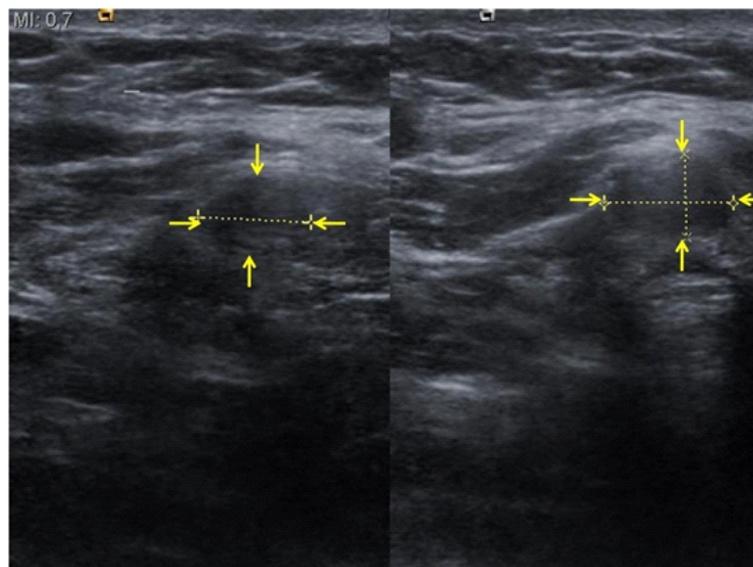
The high-resolution neck ultrasound revealed an 8 mm lesion in the anterior tracheal area.
